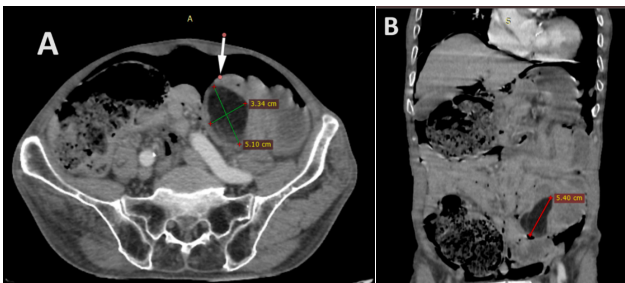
(A) Axial contrast-enhanced CT and (B) coronal view, white arrow points to a rounded endoluminal structure with maximum axial size of 54x33 mm, displaying an image of fat density of -101 Hounsfield Units (HU), suggestive of a lipoma.
